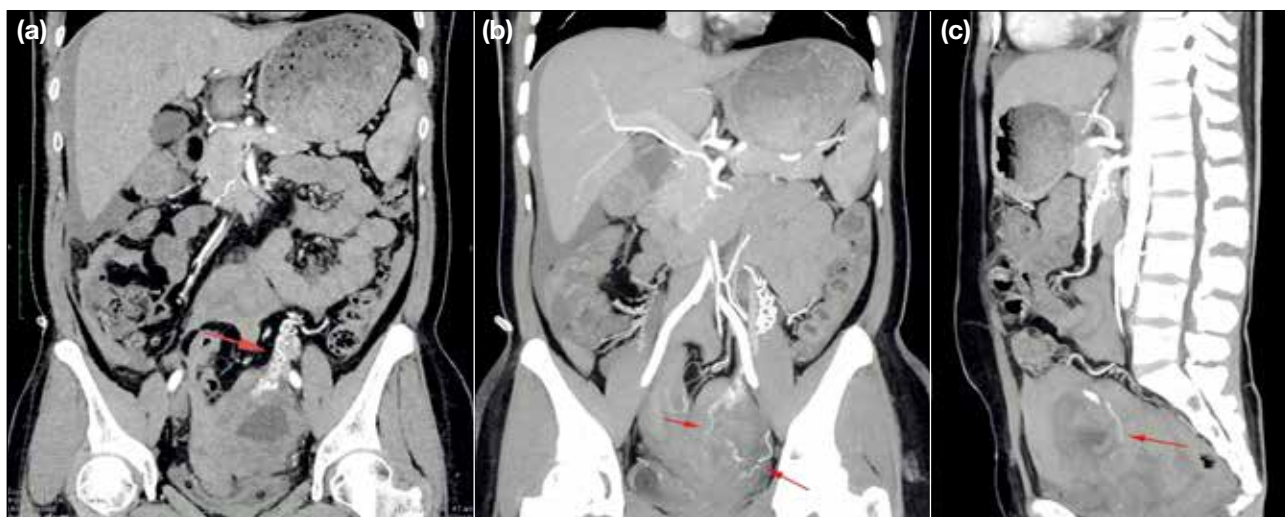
(a) Coronal computed tomography image at arterial phase showing several feeding vessels from the tortuous ovarian vessels (red arrow). Maximum intensity projection computed tomography (b) coronal and (c) sagittal images showing appearance mimicking “ring of fire” (red arrows).
